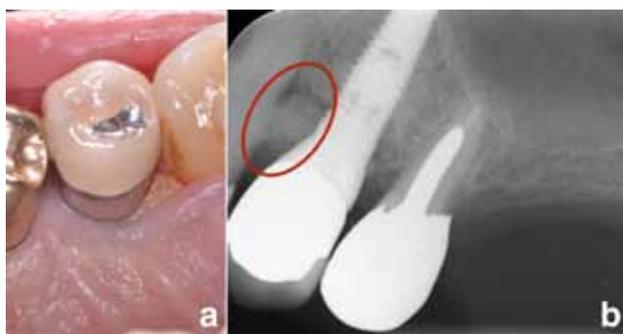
a) A bone sequestrum was visible on the mesial-palatal aspect of the implant ten weeks after the first evaluation, allowing for the diagnosis of bisphosphonates-related osteonecrosis of the jaw. b) Radiographic appearance of the bone sequestrum.
